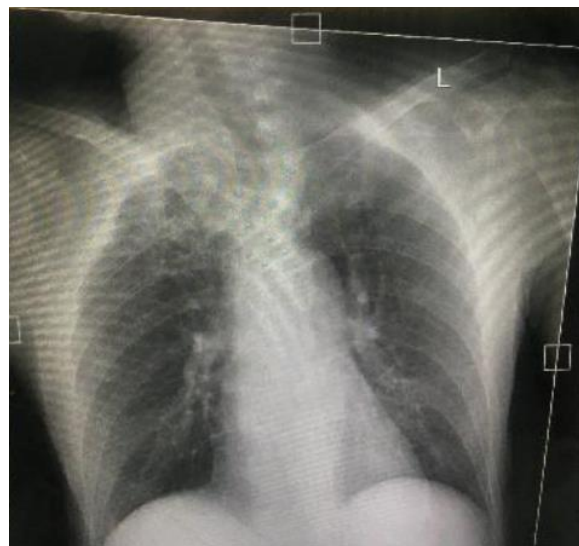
The results of the chest X-ray examination of the patient
